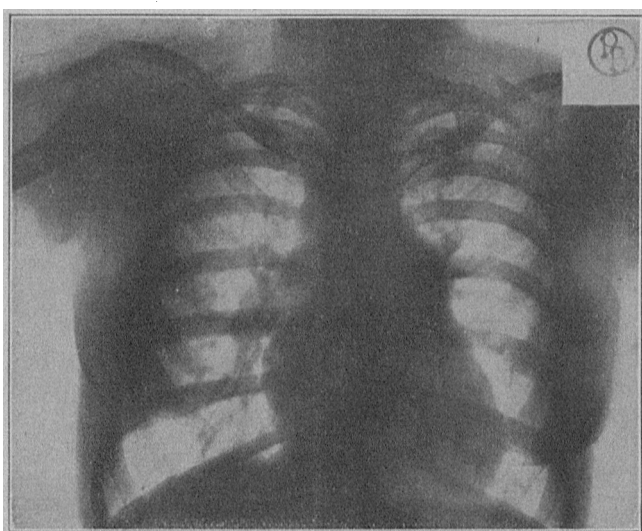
Radiograph taken by Dr. Percy Brown, Boston, three months before the death of the patient.
